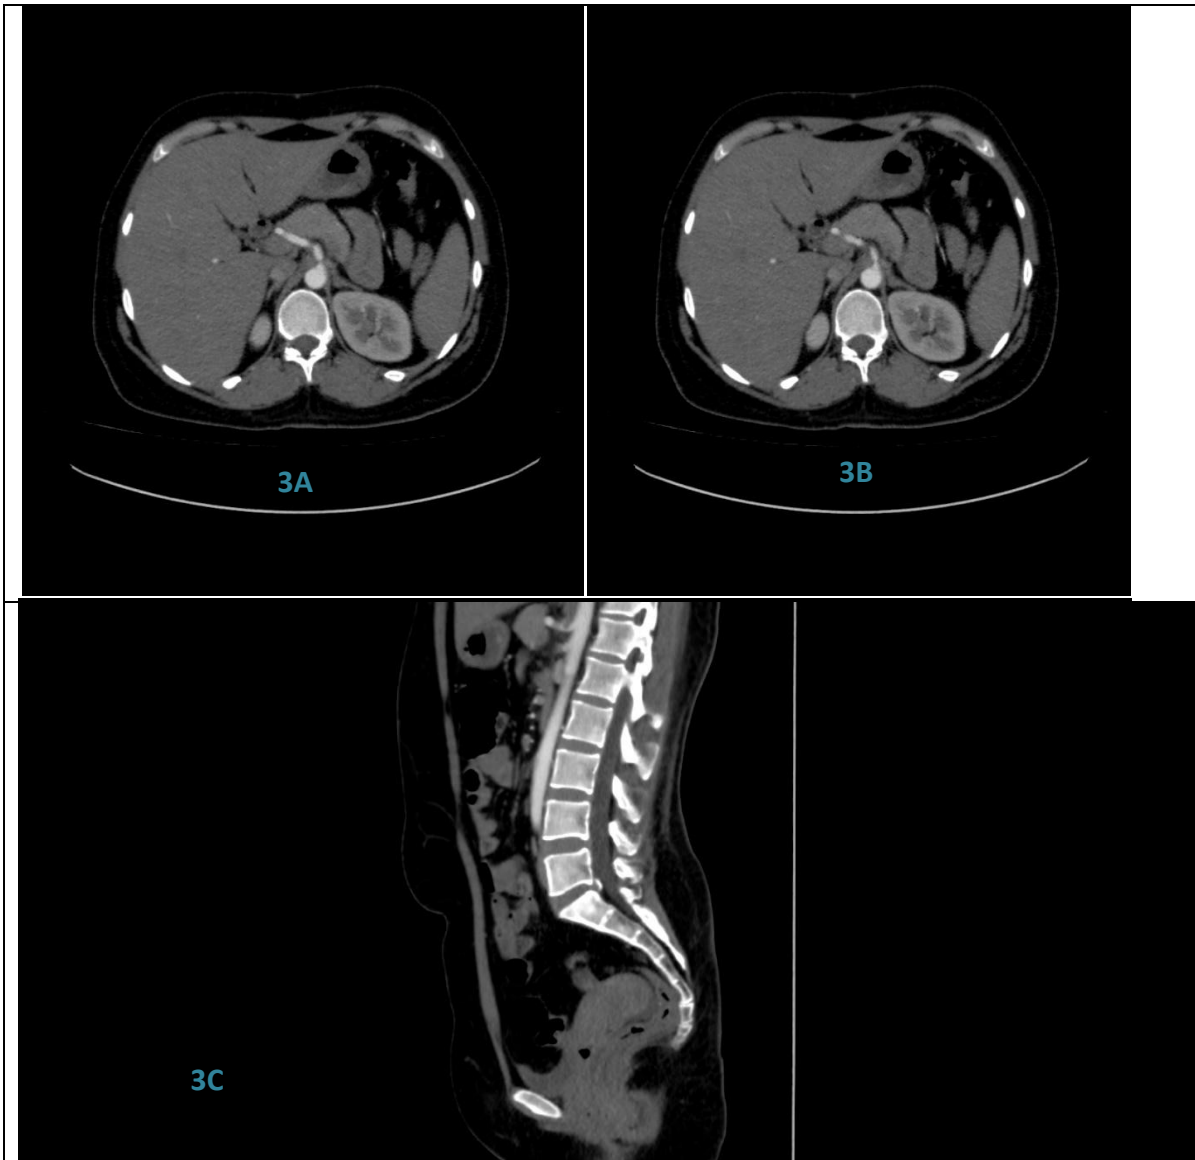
CT scan cuts of lower abdomen showing focal narrowing at celiac trunk origin due to indentation along its superior aspect
